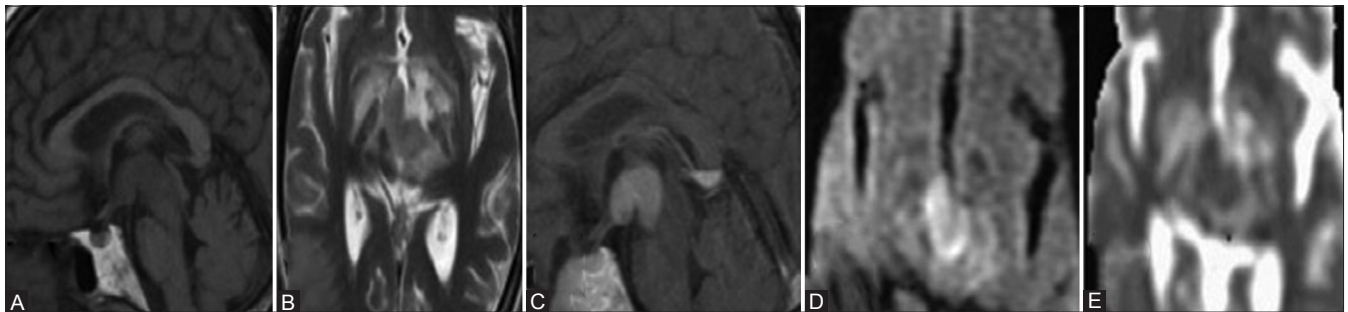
(A-E): History – A 58-year-old immunocompetent lady presented with history of headache and right-sided weakness for 4 months. On MRI, there was a lesion involving hypothalamus and midbrain which was isointense on T1 W (A), hypo intense on T2W (B) images with homogenous contrast enhancement on post-contrast study (C). Restricted diffusion noted within the lesion on diffusion weighted and apparent diffusion coefficient images (ADC) images (D and E)
